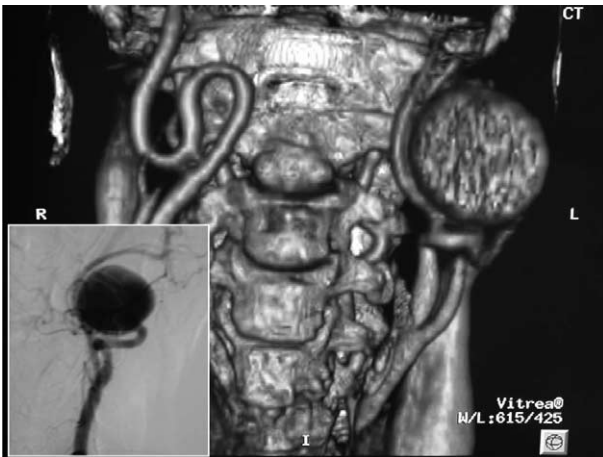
Spiral CT scan 3D reconstruction, showing the giant ICA aneurysm. In the little square the aneurysm seen with the angiography.
